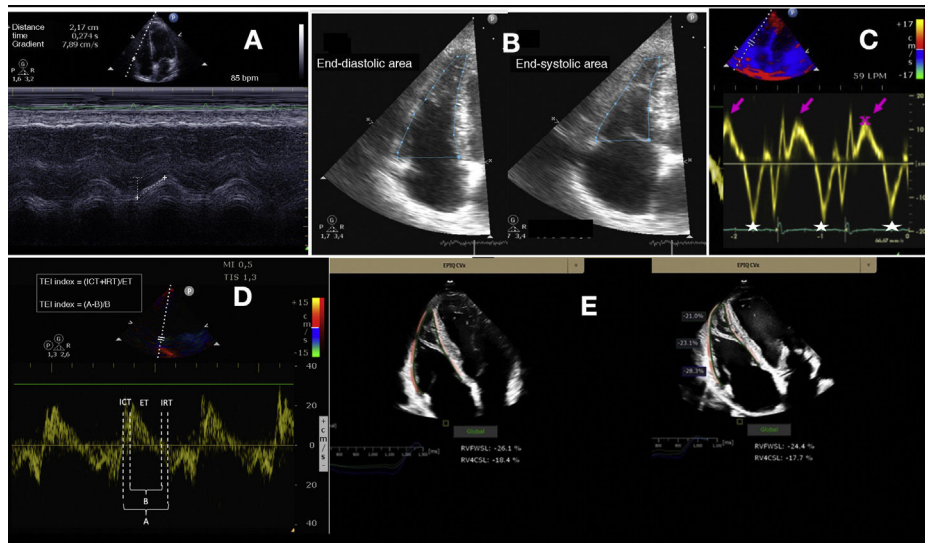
A. TAPSE. B. FAC. C. Tissue Doppler. The arrow indicates the systolic wave and the star indicates the velocity of the wave. D. TEI index: measures the ratio between the isovolumetric contraction and relaxation times in relation to systolic ejection. It can be quantified with pulsed Doppler or from the tissue Doppler registry. The advantage of tissue Doppler is that it can record all the information of the cardiac cycle in the same beat, and improves the reproducibility of the technique. Measurement is made of the isovolumetric contraction time (ICT), the isovolumetric relaxation time (IRT) and the ejection time (ET) in the pulsed tissue Doppler spectrum of the lateral tricuspid annulus. E. Strain.
